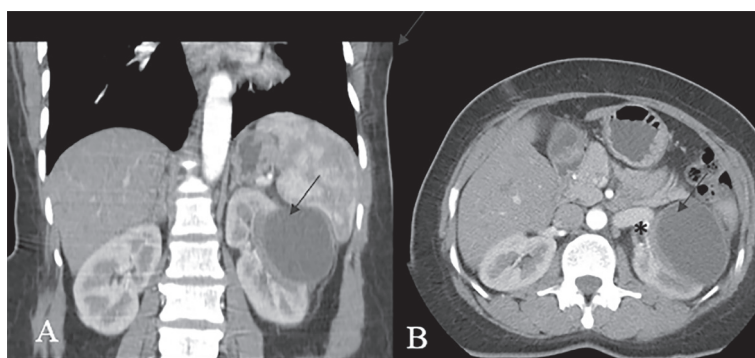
Renal hydatid disease is shown in a 54-year-old woman with flank pain and intermittent hematuria lasting for several months. Ultrasonography revealed a thin-walled cyst with no interior solid component in the mid-pole of the left kidney. Coronal (A) and axial (B) contrast-enhanced abdominopelvic CT images show a unilocular thin-walled cyst in the interpolar region of the left kidney (arrow) with no enhancing solid components in the arterial phase, compatible with Bosniak type I renal cyst. Ultrasound-guided percutaneous drainage of the cysts was performed, and aspirated fluid serology was positive for *Echinococcus granulosus*. This figure was obtained from a patient admitted to the authors' institution and was not previously published elsewhere.
